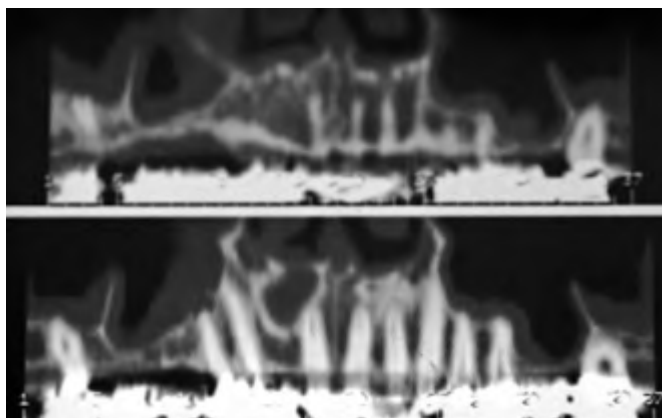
Preoperative CT scans (panoramic views). These two images were taken at different planes, several millimeters apart. The most significant finding was the severe pneumatization noted in the right maxillary sinus.
